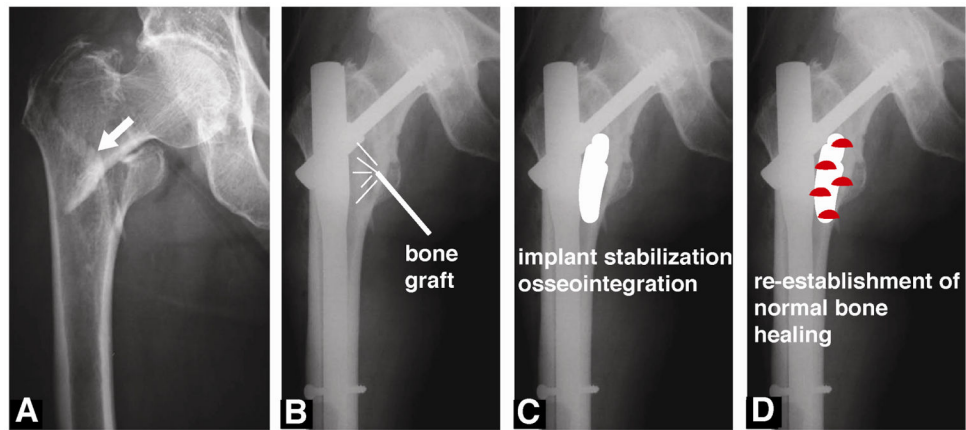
Strategies for healing osteoporotic and cancer-induced bone disease (CIBD) fractures (A) Pre-operative radiograph of a hip fracture (arrow) in an 84 year-old female patient. (B) Postoperative radiograph showing fixation of the fracture with an intra-medullary hip lag screw coated with hydroxyapatite (HA). (C) Stabilization and osseointegration of implants using osteoconductive bone grafts. (D) Re-establishment of normal bone healing by local delivery of biologics (e.g., mesenchymal stem cells, rhBMP-2, or platelet-rich plasma (shown in red)) from bone grafts and scaffolds. Adapted from A Moroni et al. Can we improve fixation and outcomes? Use of bone substitutes. *J Orthop Trauma* 23:422–425, 2009 [29].
